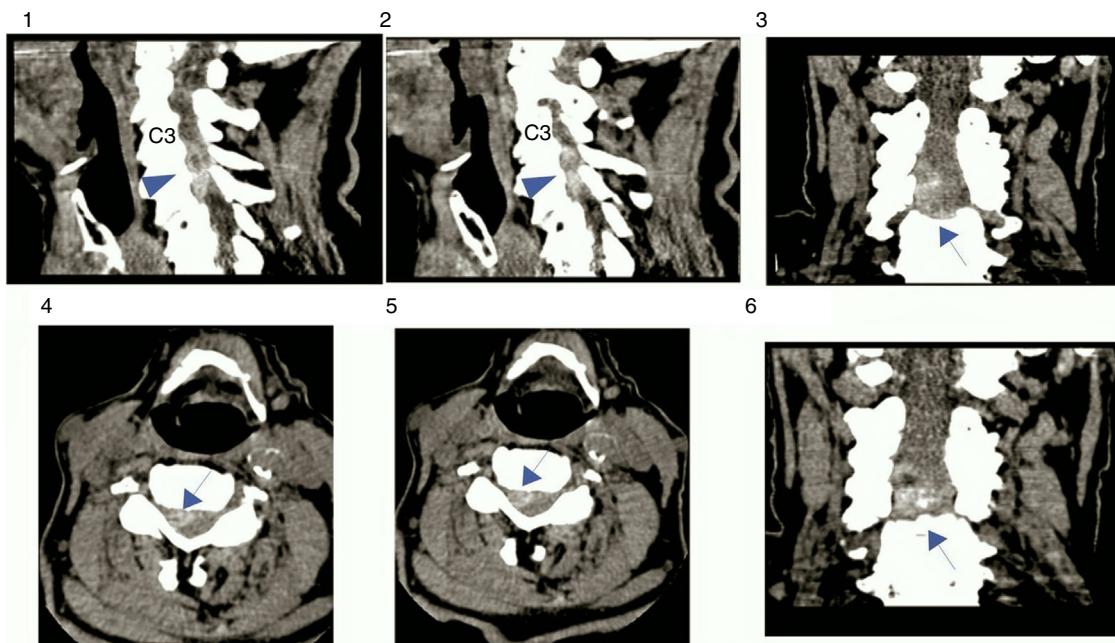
Radiological imaging of cervical subarachnoid hematoma. Cervical CT. A big acute cervical spinal hematoma, probably epidural type. (1.A) and (1.B.) Arrowhead: C3-C5 cervical hematoma. (3.C), (4.D), (5.E), (6.F) Arrow: right anterolateral hematoma.
